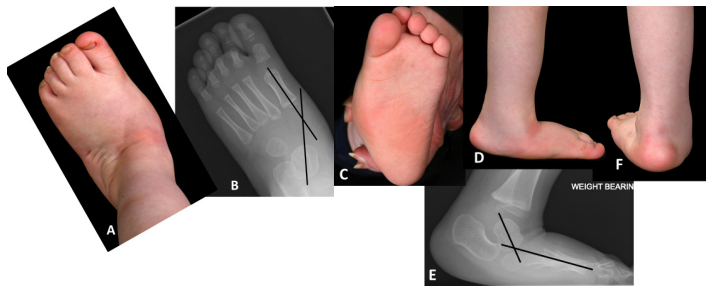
A. Hyper-abducted clubfoot in a 3-year-old who had been serial casted. B. AP radiograph of the foot showing the foot-CORA in the unossified medial cuneiform, i.e. metatarsus ABductus. The talo-navicular joint is likely reduced in this case, based on the location of the foot-CORA. C. Plantar view. D. Standing lateral view. E. Weightbearing lateral radiograph. The hyper-dorsiflexed foot-CORA at the talonavicular joint indicates an associated rocker bottom deformity. F. Posterior view of the foot. (Images courtesy of Donald Campbell, MD from Dundee, Scotland who was consulted regarding management of this iatrogenic deformity that was created elsewhere)
